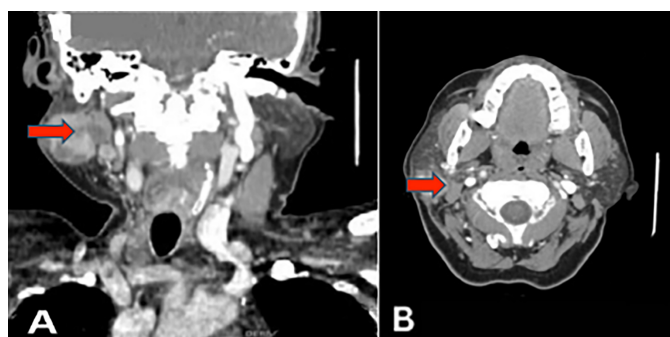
(A) Coronal CT scan. (B) Axial CT showing right parotid gland enlargement.
